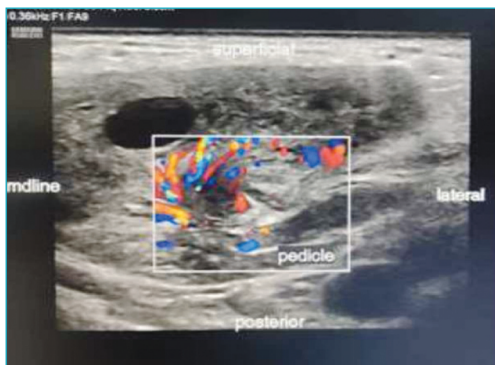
The left ovary is seen lying in the subcutaneous plane in the left inguinal region with its vascular pedicle. On examination with colour Doppler, there was no tortuosity in the pedicle.
